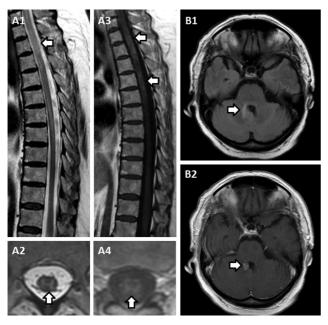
MRI features of myelin oligodendrocyte glycoprotein IgGassociated disease. Sagittal T2-weighted thoracic spine MRI showing a longitudinally extensive T2-hyperintense lesion (A1, arrow), predominantly affecting the gray matter in a pattern suggestive of an "H sign" on axial T2-weighted sequences (A2, arrow). Sagittal (A3) and axial (A4) T1-weighted post gadolinium sequences show a nonspecific enhancement pattern (arrows). MRI of the brain shows a T2 hyperintense lesion near the 4th ventricle and right superior cerebellar peduncle on T2 FLAIR-weighted sequences (B1, arrow) with associated enhancement on T1-weighted post gadolinium sequences (B2, arrow).
